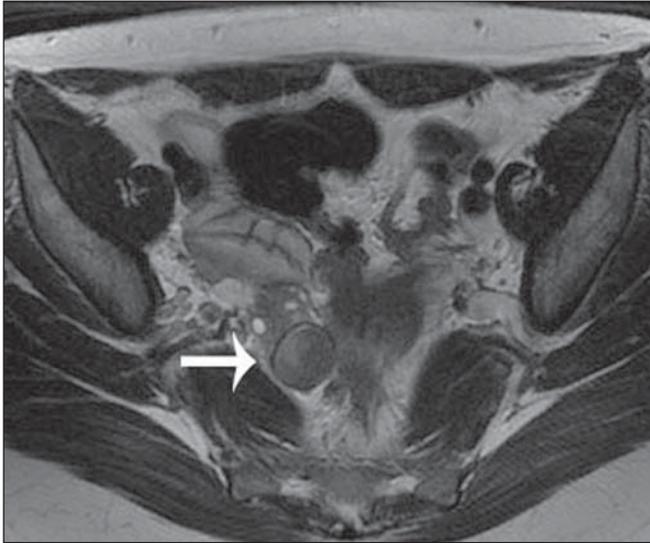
Endometrioma. Axial MRI T2-weighted sequence acquired with a 1.5 T scanner, demonstrating signal loss as compared with the T1-weighted sequence.
